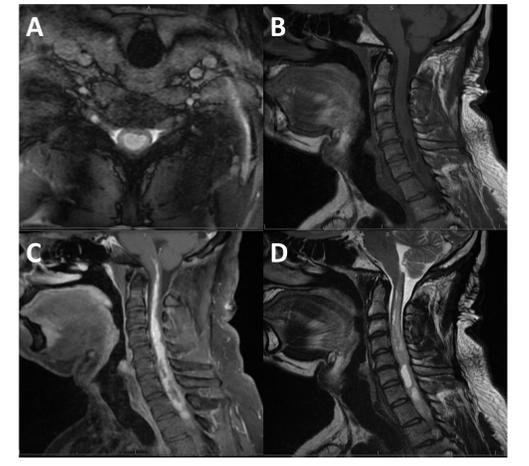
Cervical MRI with and without contrast demonstrating a large syrinx in the cervical and upper thoracic cord with nodular regions of enhancement and septations. Panel A: Axial 3D Cosmic at C7 level. B: Sagittal T1 FSE (Fast Spin Echo). C: Sagittal T1 FLEX + Gadolinium. D: Sagittal T2 FSE
